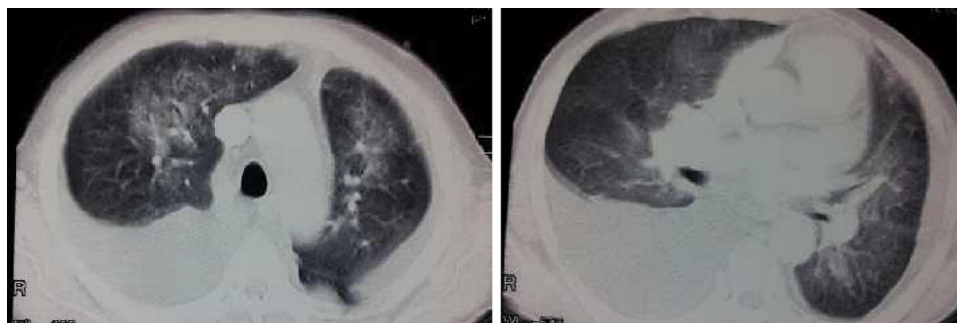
Chest CT of patient at time of presentation.
